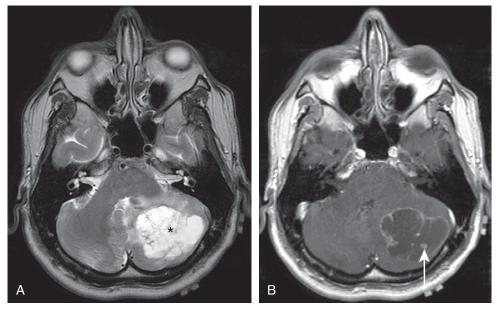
Necrotic metastatic tumor in a patient with a history of stage 1 non-small cell lung carcinoma treated 1 year prior. (A) Axial T2-weighted image demonstrates a cystic cerebellar lesion (*) with internal septations and perilesional edema. (B) Postcontrast axial T1-weighted image with contrast demonstrates a cystic cerebellar mass with predominantly peripheral smooth and nodular enhancement. There are also three internal enhancing nodules (arrow).
